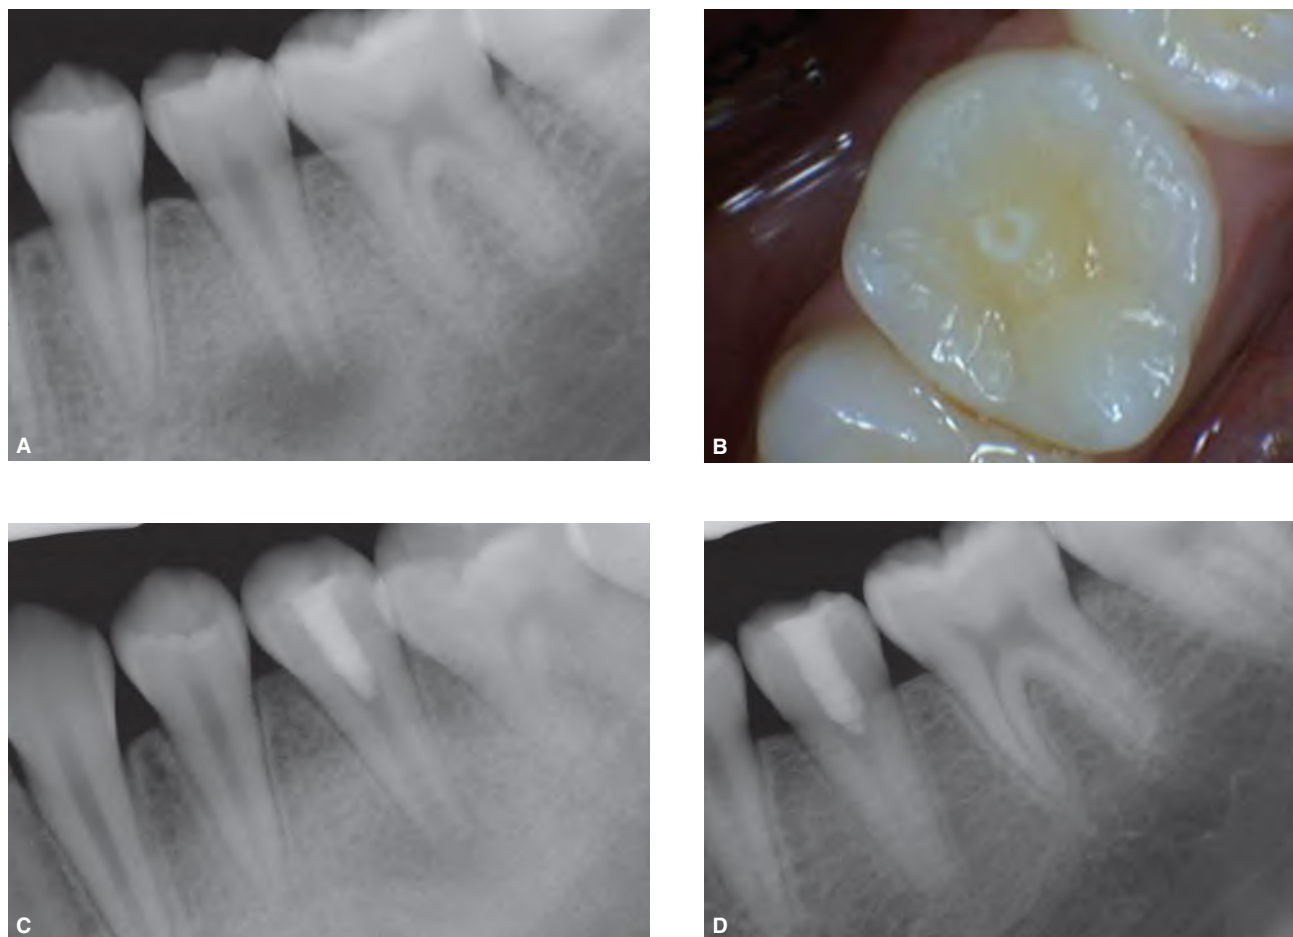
Dens evaginatus in a mandibular second premolar of a 12-year-old male. Patient complained of pain while biting on his left side. Pulp sensibility tests were negative. A. Preoperative radiograph showing periapical radiolucency associated with the tooth. B. Clinical view showing fractured occlusal protuberance (arrow). This frequent occurrence causes pulpal irritation, and often pulp necrosis at an early age. Pulp regeneration therapy with a triple antibiotic paste was performed (for more details about this procedure, see Chapter 29, "Regenerative endodontics"). C. Immediate postoperative radiograph. D. 18-month recall radiograph showing evidence of active bony healing. Note the narrowing of the pulp space. The patient was asymptomatic and the pulp responded positive to sensibility tests. (Courtesy of Dr. Rajiv G. Patel, Flower Mound, TX.)
